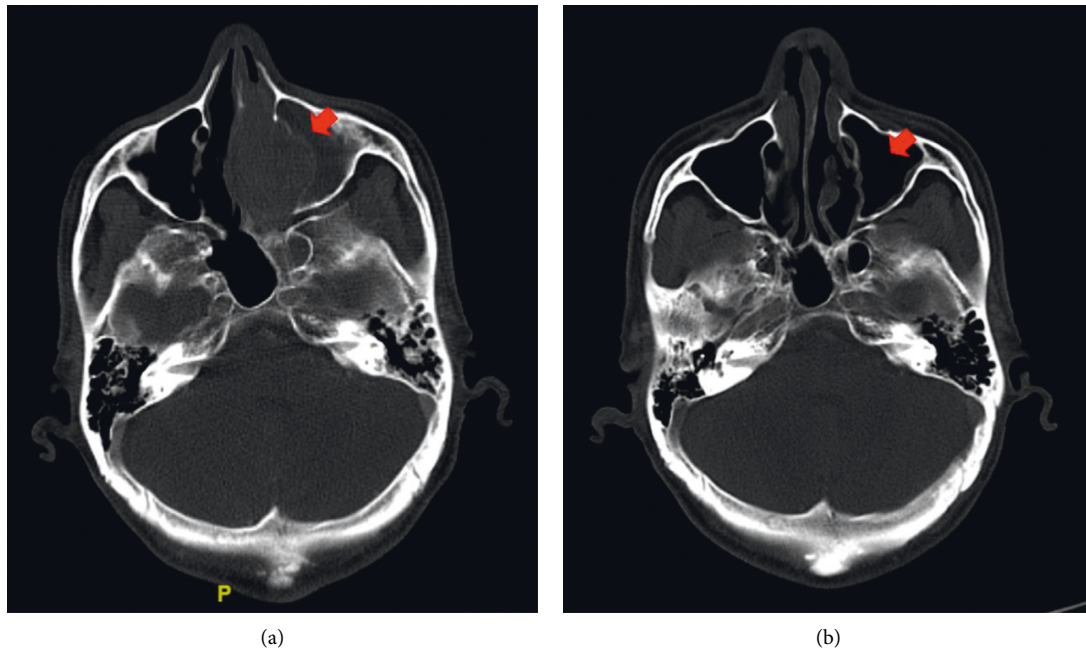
Initial CT showing a mass over left frontal and ethmoid sinuses which occupied almost the entire left nasal cavity (a). Repeated CT showing regression of left nasal mass (b).
